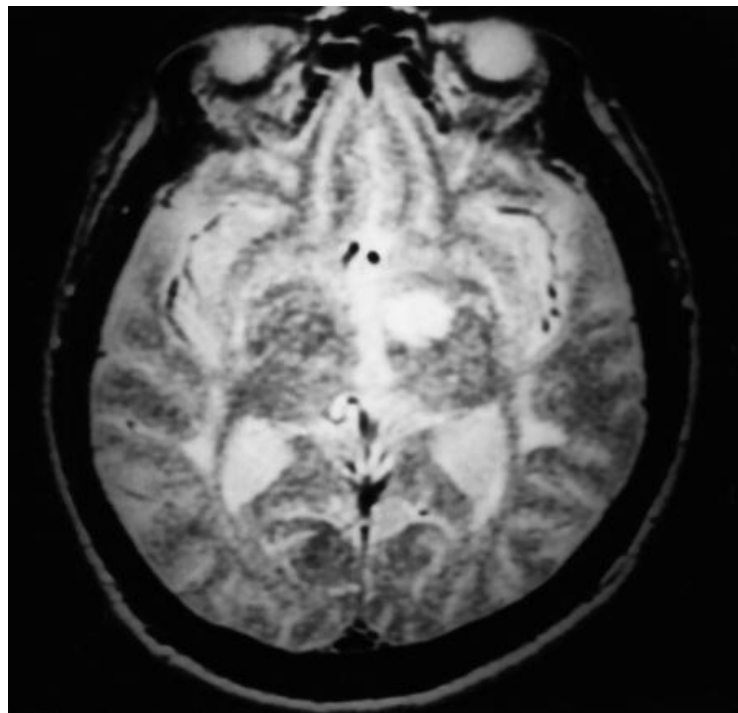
T2-weighted MRI scan showing unilateral left polar (tuberothalamic) infarction.
